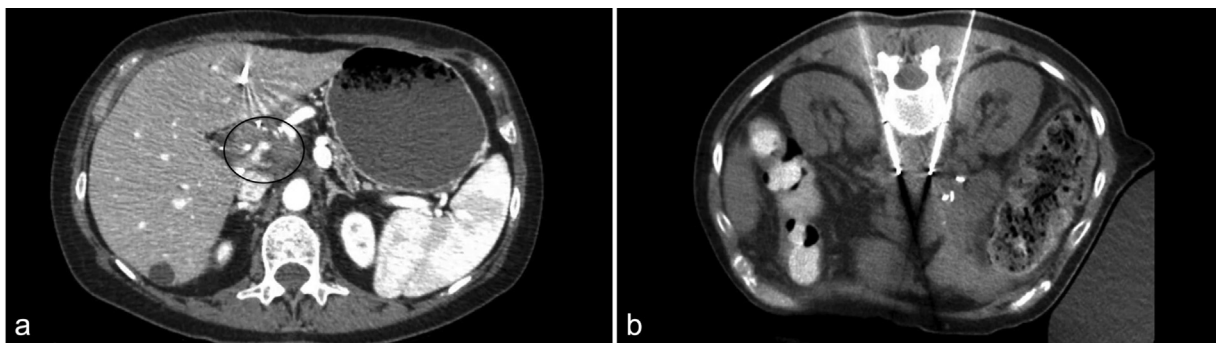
CT-guided celiac plexus cryoneurolysis in a patient with pancreatic cancer. (a) Contrast-enhanced CT demonstrating pancreatic head malignancy (black circle). (b) Intraprocedural CT images demonstrate two cryoprobes positioned through a posterior approach in the antecrural position.
